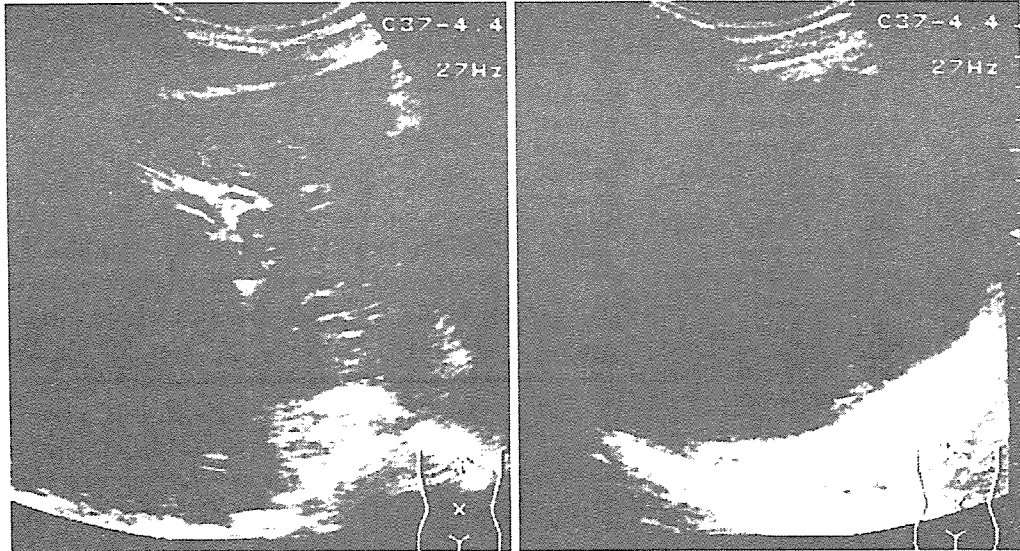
Abdominal ultrasound. A large cystic lesion is located in the right hepatic lobe. The content is homogeneous, without a septum or calcifications, and the intrahepatic bile ducts are dilated.
